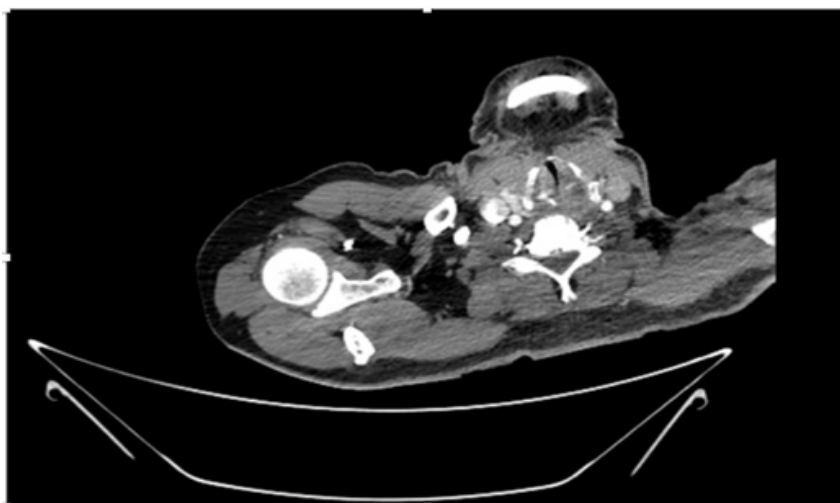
CT Angiogram at neck showing totally occluded right subclavian artery.
